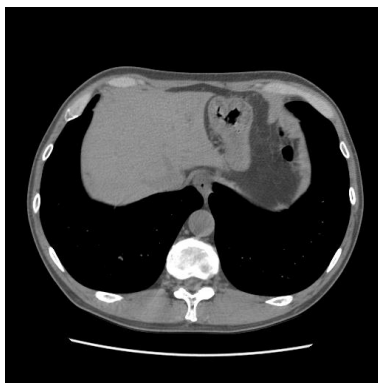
A result of each region segmented manually. (a) An axial slice of non-contrast X-ray CT image (a part of abdomen), (b) segmented each tissue (blue: right hepatic lobe, red: left hepatic lobe and green: IVC: Inferior vena cava) region segmented manually from (a), and (c) 3D image of (b).
